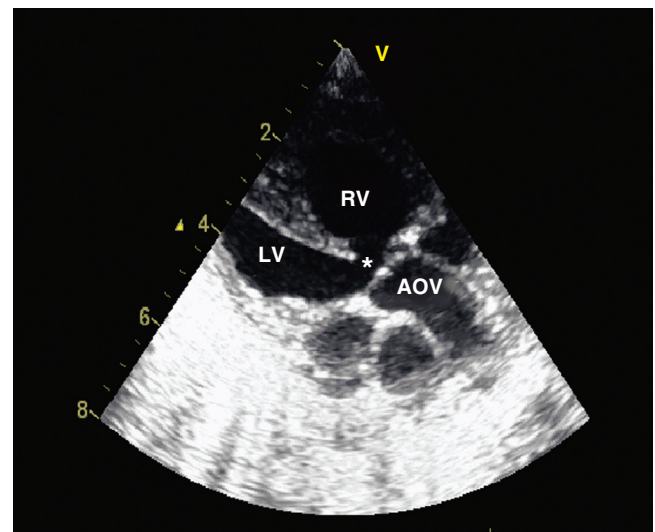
■ Preoperative two-dimensional echocardiographic image, long-axis view, showing the degree of overriding of the aortic valve across the ventricular septal defect (asterisk). AOV, Aortic valve; LV, left ventricle; RV, right ventricle. (Courtesy Professor Ornella Milanese.)
